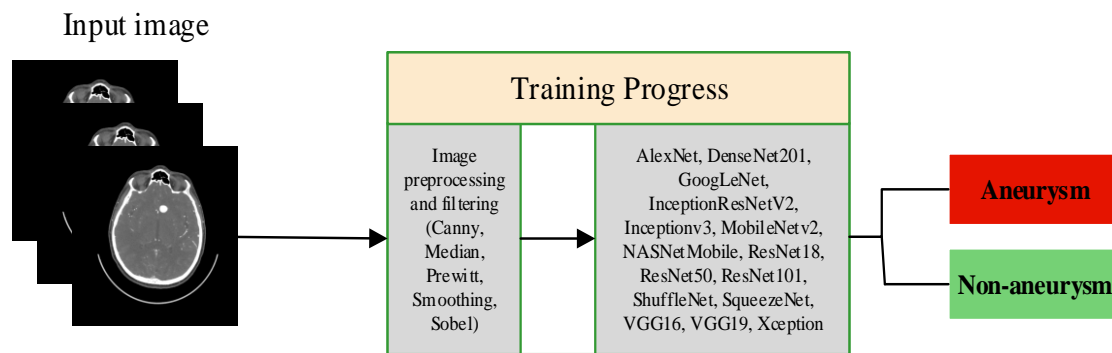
Classification of filtered CTA images
